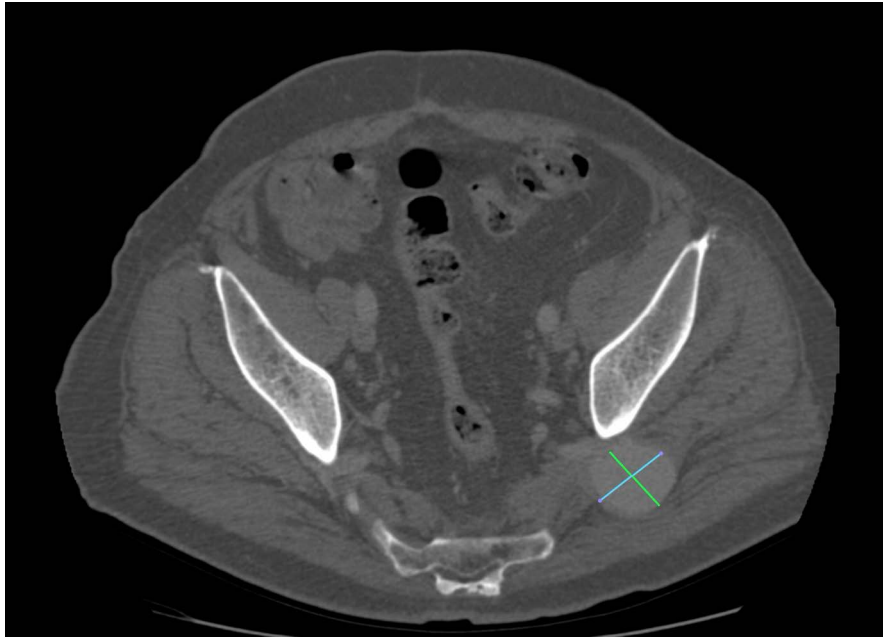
69-year-old male with mycotic pseudoaneurysm of the left SGA. CT (December 2018) of the abdominopelvic cavity shows the pseudoaneurysm of the left SGA of 36x33mm.
